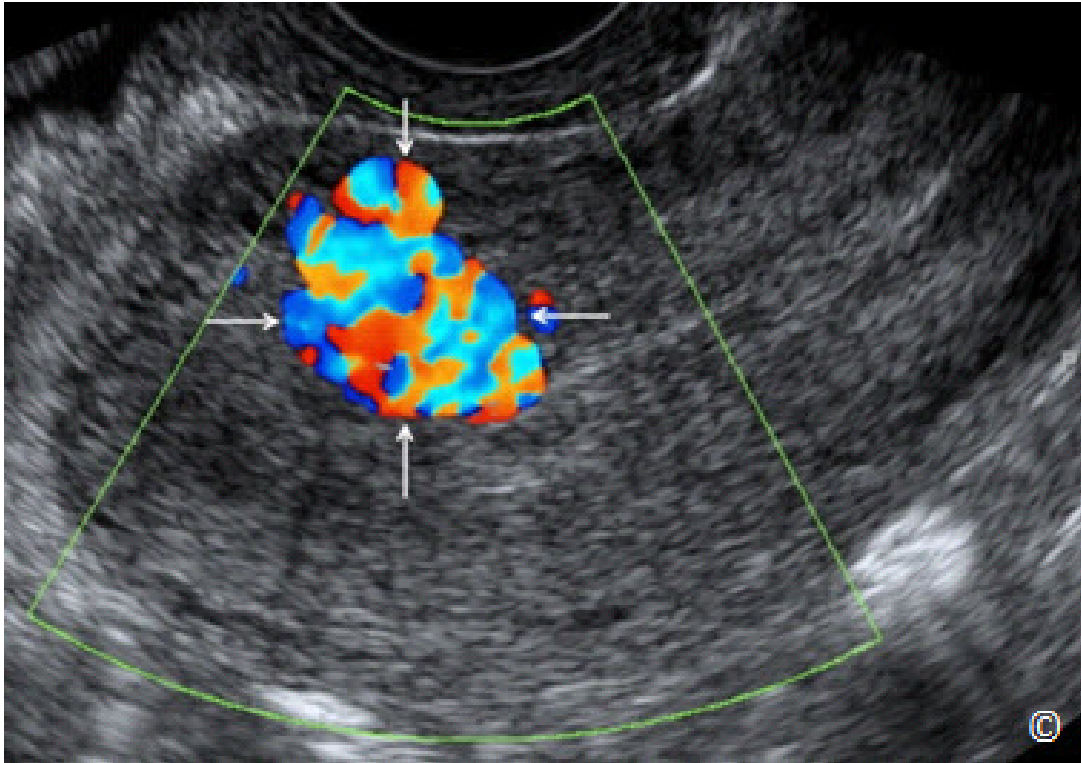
Transvaginal ultrasound with color Doppler of a sagittal plane of the uterus showing the same arterio-venous malformation (AVM) (arrows) as that in Figure 11.43. Note the presence of blood flow within the AVM with turbulence and aliasing.
